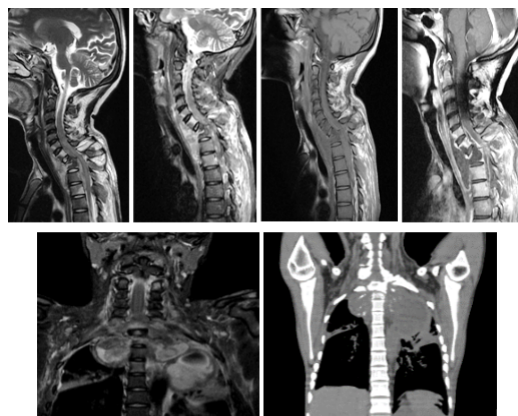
18 year old girl with history of fever, loss of weight and gibbus deformity. A – D MRI images of the cervico-dorsal spine shows, collapse with destruction of D1 to D2 vertebral bodies resulting in acute kyphosis of dorsal spine with retropulsion of bony fragments indents thecal sac causing compression of cord parenchyma opposite to D1-D3 level with spinal canal and altered signal intensity opposite to C6 to D5 levels. E Post-contrast Coronal T1Wi shows peripherally enhancing abscess in the prevertebral space from C6 to D5 level, epidural abscess (from C7 to D5 level), right paraspinal abscess and contiguous extension into right paravertebral abscess and left paravertebral abscess with air fluid level and thick wall. Amorphous calcification in the pre and paravertebral abscess, likely to be long standing disease process (CT correlated). Minimal inflammatory fluid along the Prevertebral space opposite D6-D9 levels. Altered marrow signal intensity from C6 to D5 vertebral bodies including posterior elements and costovertebral junction. Extensive bilateral paraspinal soft tissue edema at dorsal levels and root of neck - Features are of tubercular spondylodiscitis.
